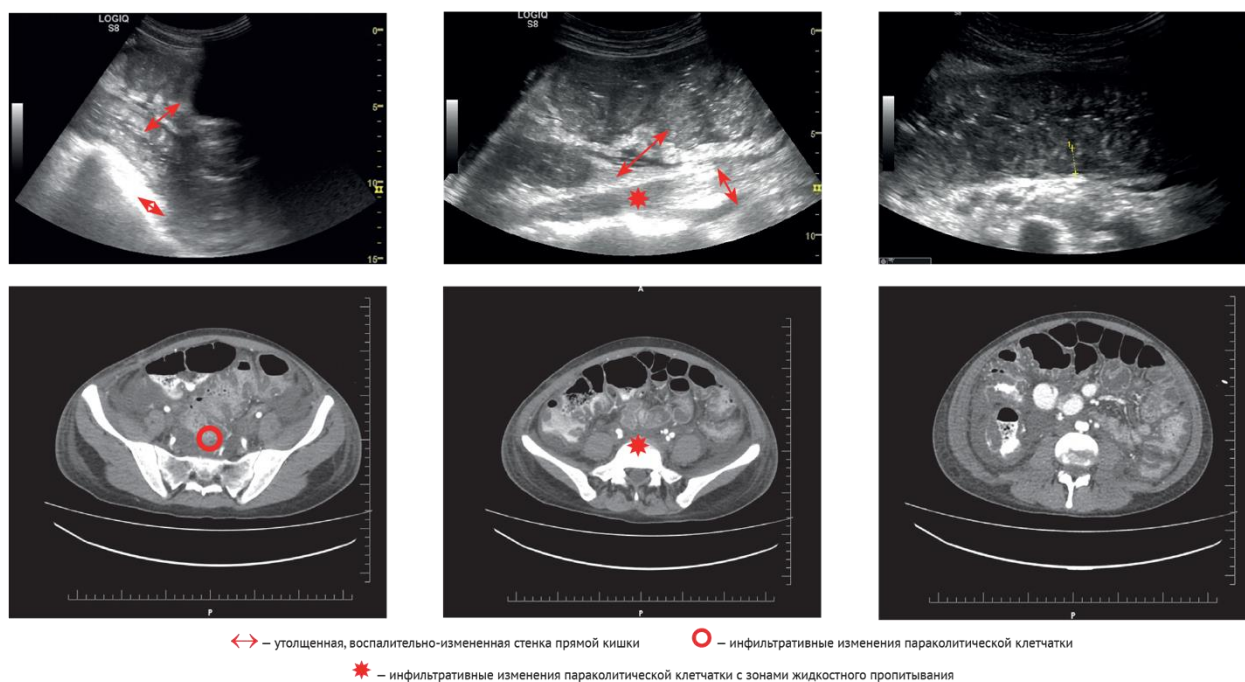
Ultrasonograms and CT images of abdominal organs of patient G. — signs of severe pseudomembranous colitis
